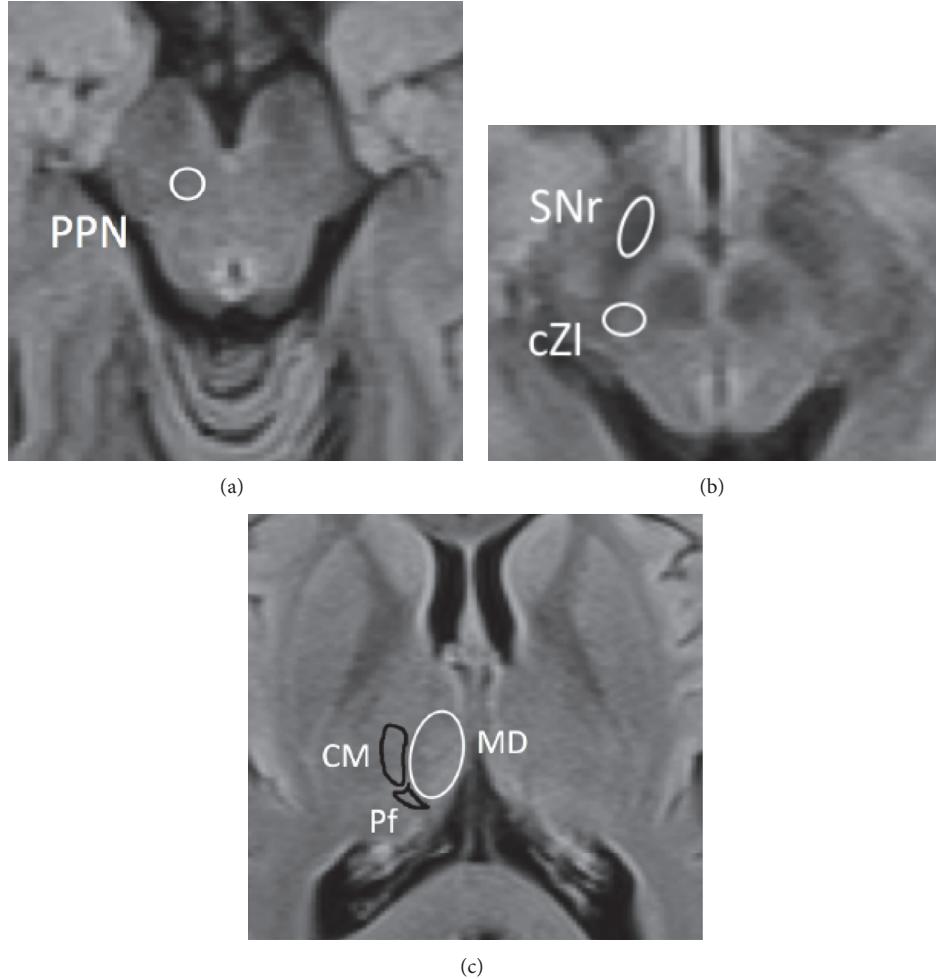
Axial MRI imaging at the level of the midbrain and thalamus, demonstrating the anatomical locations of DBS targets described in the review. CM-Pf, centromedian-parafascicular nuclear complex; cZI, caudal zona incerta; PPN, pedunculopontine nucleus; SNr, substantia nigra pars reticulata.
